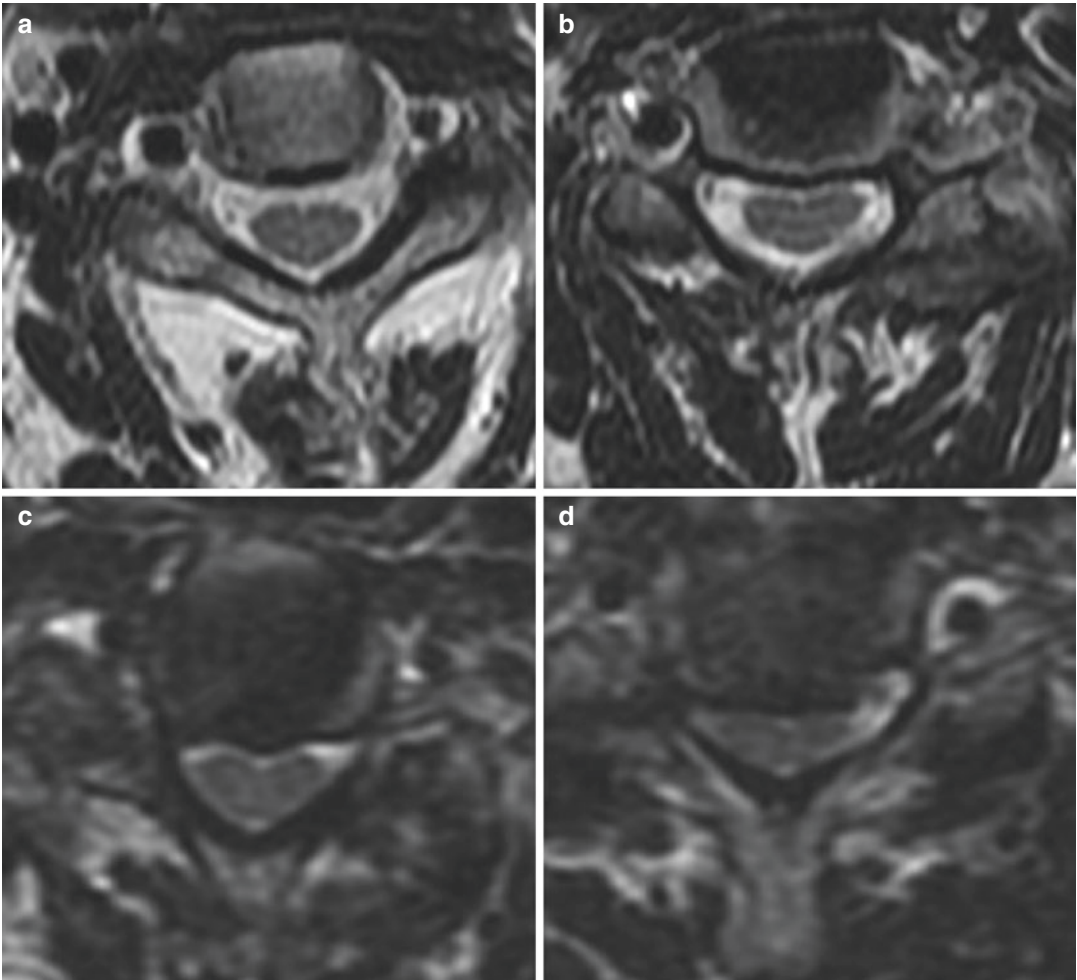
Axial (a–d) T2-weighted images of the cervical spine. In contrast to the normal central canal (a), in mild central canal stenosis (b), there is mild effacement of the surrounding CSF space, which may or may not be bilateral. In moderate central canal stenosis (c), there is usually an associated deformity of the thecal sac or spinal
